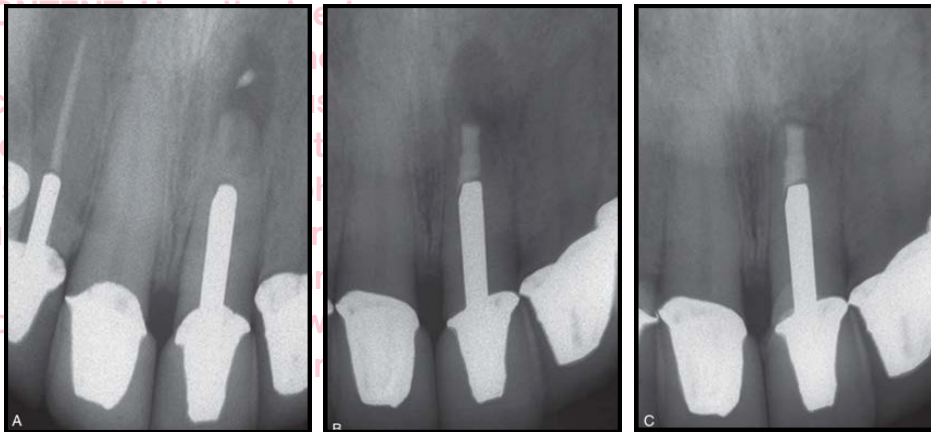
Image- A, Failed root canal treatment in the left maxillary lateral incisor requires periapical surgery. B, the root end is resected; a cavity is prepared and filled with MTA. C, Postoperative film after 1 year showing complete healing (Source-Walton)
